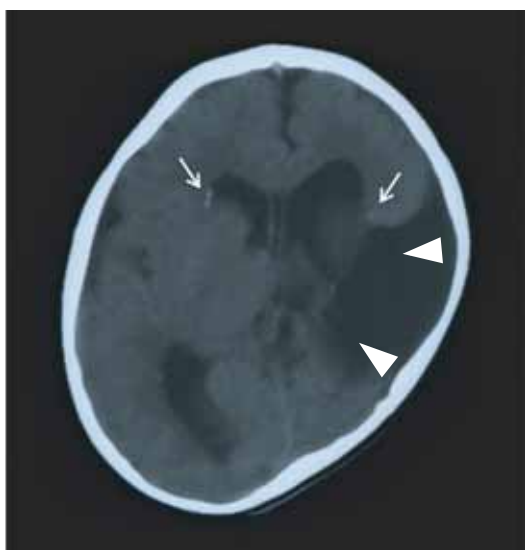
The brain computed tomography of Case 1 showed porencephaly (arrowhead) and intracranial calcification (arrow) at age of 4 months.
